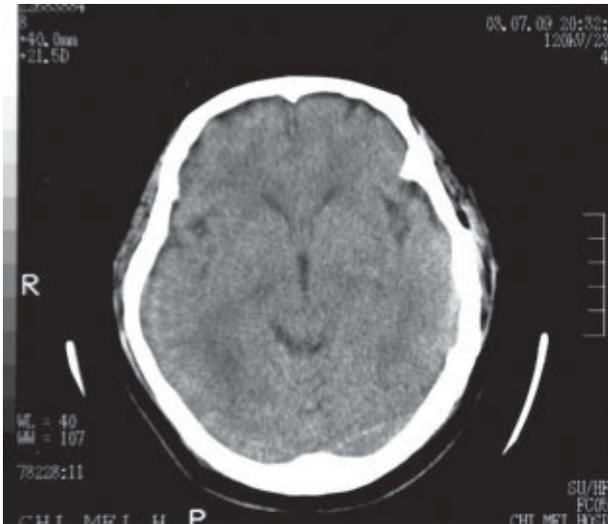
Initial brain computed tomography was unremarkable.
